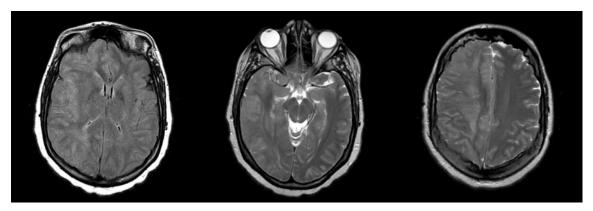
Axial FLAIR MRI and Axial T2 weighted MRI on post-operative Day 2.
